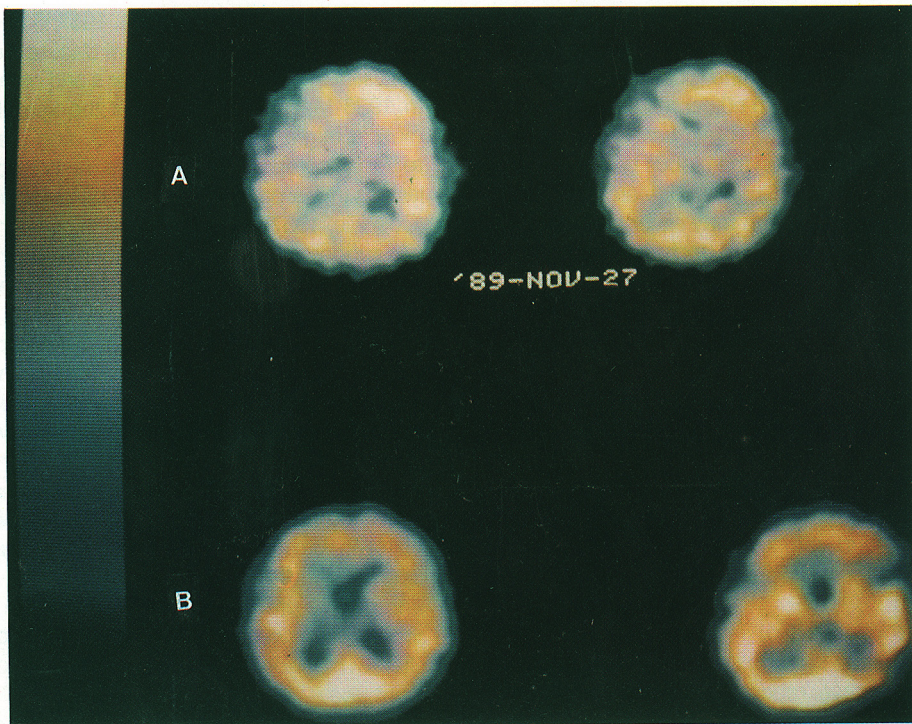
A. SPECT with  $^{99m}\text{Tc}$ -HM-PAO 7 days after delayed neurologic sequelae of CO poisoning showed decreased perfusion throughout the cerebral cortex, more prominently on the left side. B. SPECT with  $^{99m}\text{Tc}$ -HM-PAO six and a half months after A showed markedly increased perfusion with the concomitant clinical improvement (patient 1).
